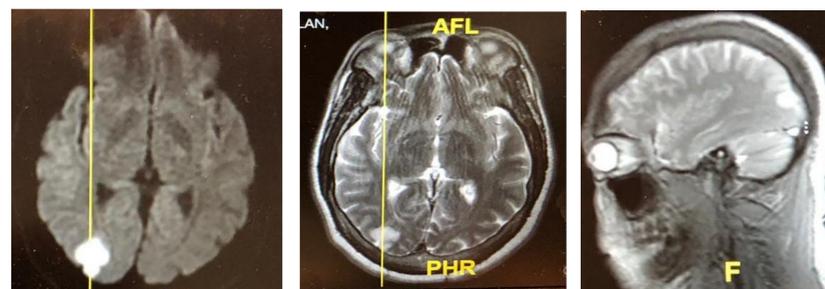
MRI showing an area of acute ischemia in the cortex of the right occipital lobe and white matter of the right parietal lobe.
